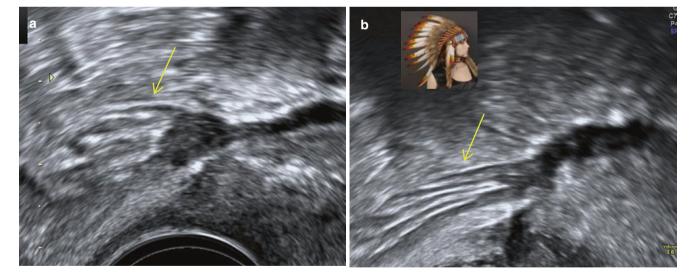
(a, b) 'Red Indian hair dress' sign seen in two different cases of bowel DIE. The images show hyperechoic linear echoes (*arrows*) radiating out from the DIE nodule resembling a 'Red Indian hairdo'. This typical feature is prominent on ultrasound and is therefore helpful in picking up DIE lesions
